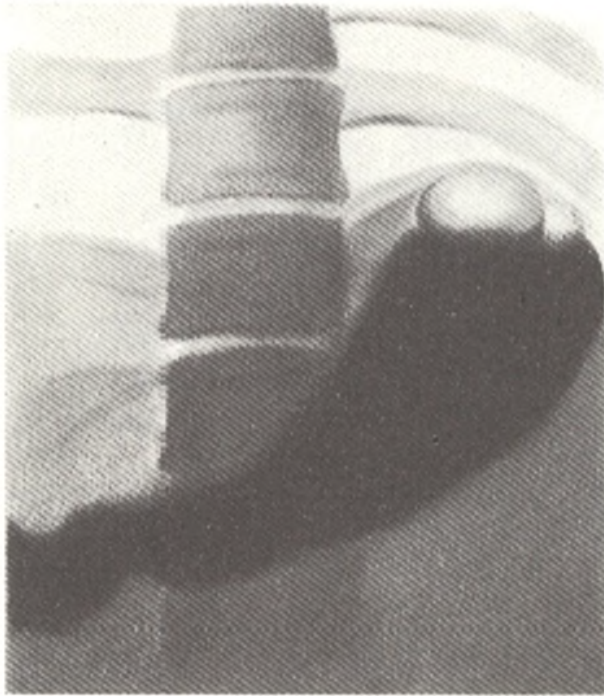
Horn-shaped stomach (radiograph)
